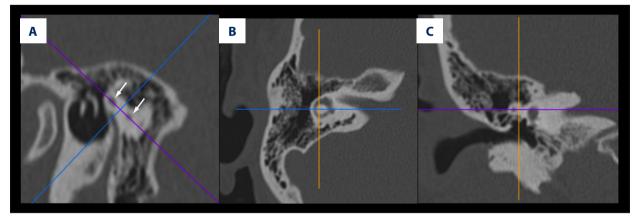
Standardization of the axial plane (B) using the "two-dots" technique in multiplanar reformatting reconstruction of computed tomography data. After identification of the lateral semicircular canal in the sagittal plane (A), an axial cross-reference line (purple line) was drawn through two dots (arrows) that represent the anterior and posterior branches of the lateral semicircular canal. Perpendicular to the axial line, other reconstruction plane cross-reference lines are shown: a blue line for the coronal plane (C) and a yellow line for the sagittal plane (A).
